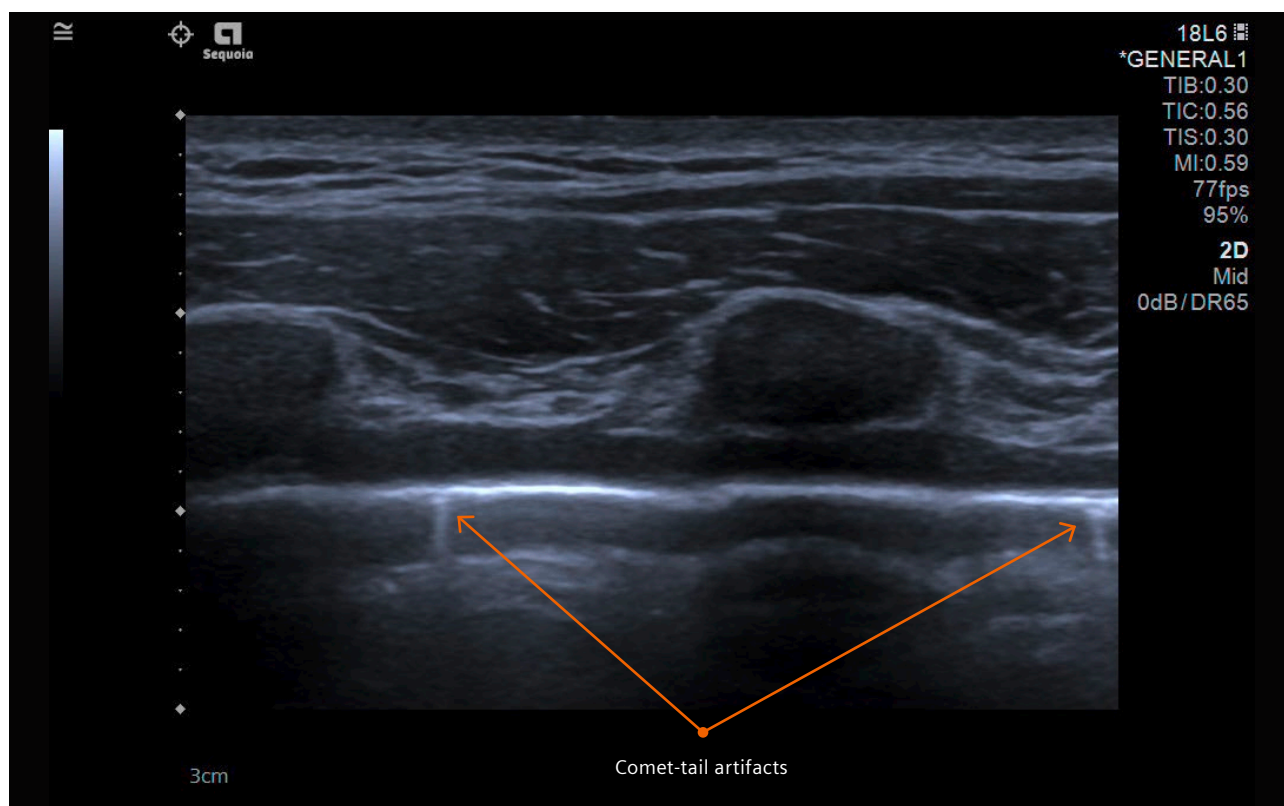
Ultrasound image demonstrating comet-tail artifacts. The artifact originates at the pleura but fades.
